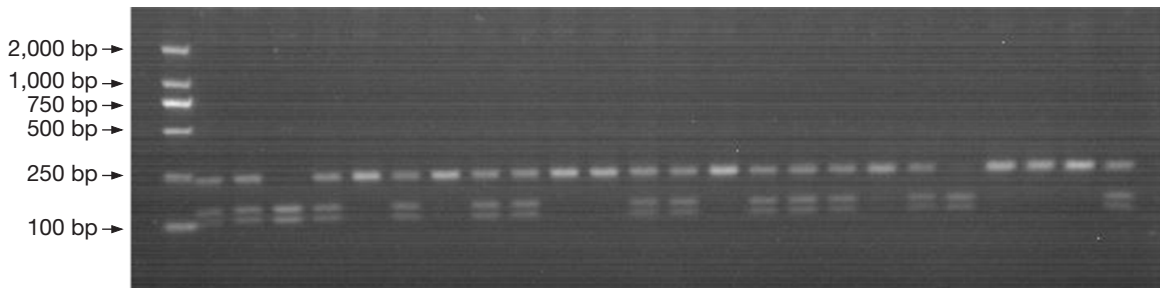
Agarose gel electrophoresis of rs6478106 digested by *Eco53KI*. Lane 1 is DNA marker; lanes 4, 21 are TT homozygote; lanes 6, 8, 11, 12, 15, 19, 22-24 are CC homozygote; lanes 2, 3, 5, 7, 9, 10, 13, 14, 16-18, 20, 25 are CT heterozygote.
